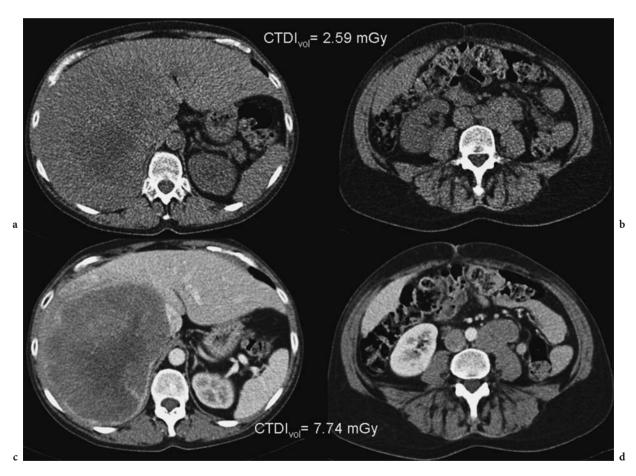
A 42-year-old woman 1.62 m tall and weighing 67 kg referred for an abdomino-pelvic CT complaining of chronic abdominal pain for 4 months. Unenhanced low-dose CT of the abdomen (a, c) and pelvis is obtained with a dose–length product (DLP) of 115 mGy·cm, equivalent to one-quarter of the mean value from the UK 2003 survey (NRPB 2005). This acquisition shows a focal hepatic mass (a) and retroperitoneal lymphadenopathies (c). Enhanced standard-dose CT confirms liver metastases and lymphadenopathies (b, d). Biopsy of the cervix confirmed adenocarcinoma. Enhanced CT delivered 300 mGy·cm, corresponding to less than one-half of the mean values from the NRPB 2003 survey study. The CT scanner was a Siemens Emotion 16° with 16×0.6 mm collimation, 130 kVp, an image quality index of 130 mAs (effective) and used an AEC device
